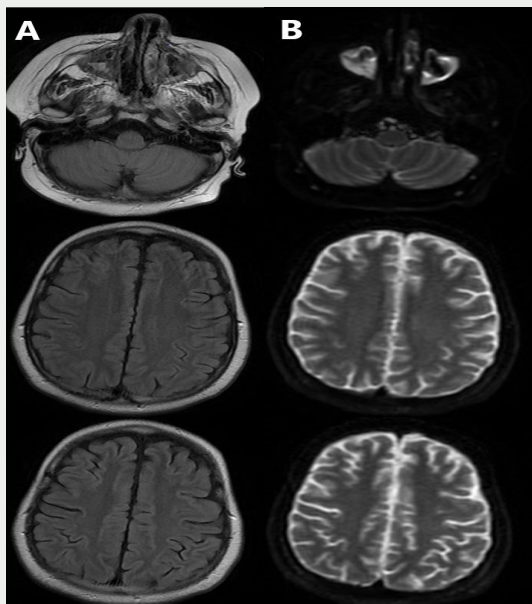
Disappearance of the signal anomalies already described in axial fluid attenuated inversion recovery - weighted (A) and diffusion magnetic resonance imaging (B)
